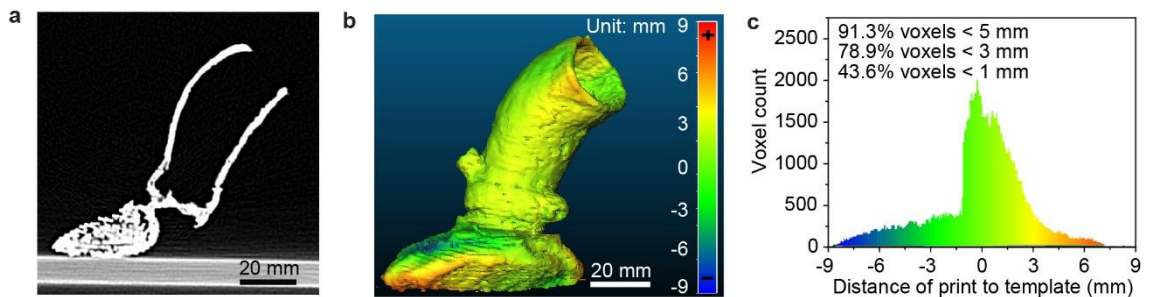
Anatomical fidelity analysis of the 3D printed aortic root model with respect to patient's data. (a) CT scan of the 3D printed aortic root model. (b) Calibrated distance map comparing the anatomical fidelity of the 3D printed aortic root model with patient's anatomy. (c) Histogram of the calibrated distances between the surface points of the 3D printed aortic root model and the patient's anatomy.
